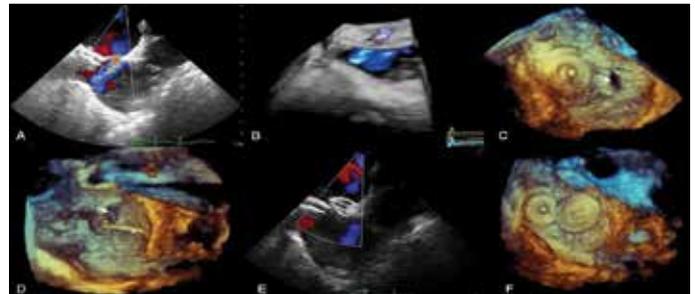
Two - dimensional transesophageal echocardiography (TEE) showing secundum atrial septal defect near the closure device (A), three-dimensional (3D) color Doppler and zoom modality TEE demonstrating the defect near the closure device (B, C), 3D zoom modality TEE showing the catheter in the defect (D) and 2D and 3D zoom modality TEE revealing successfully deployment of second septal occluder device (E, F). Arrow-atrial septal defect
